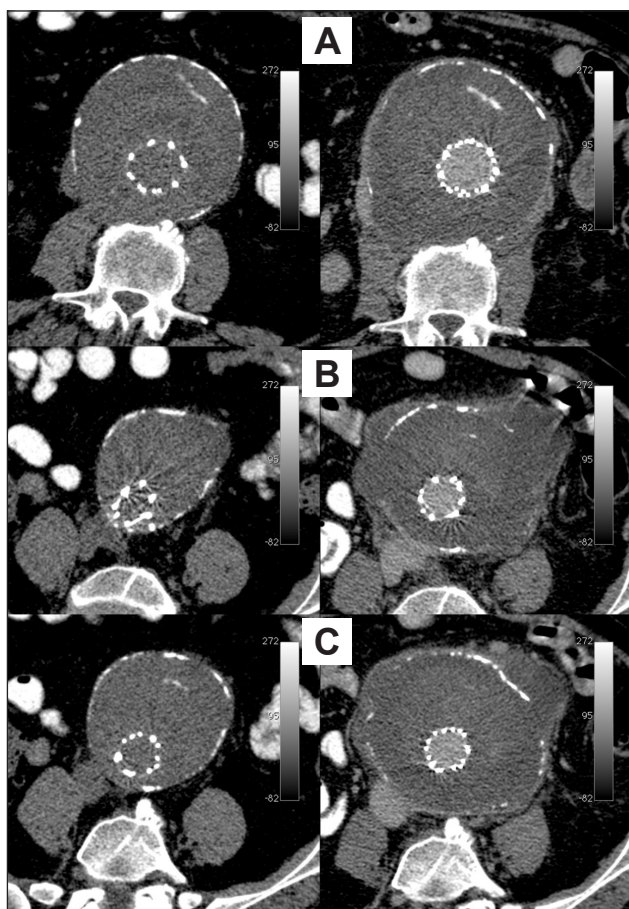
Angio-computed tomography demonstrating the ruptured wall of the aortic aneurysm without a contrast leak. Left images are noncontrasted from before rupture, and right images contrasted after rupture. A: calcium inside aneurysm sac, not to be mistaken with endoleak; B: aneurysm growth after the procedure and point of rupture; C: ruptured aneurysm without bleeding or contrast leak.
